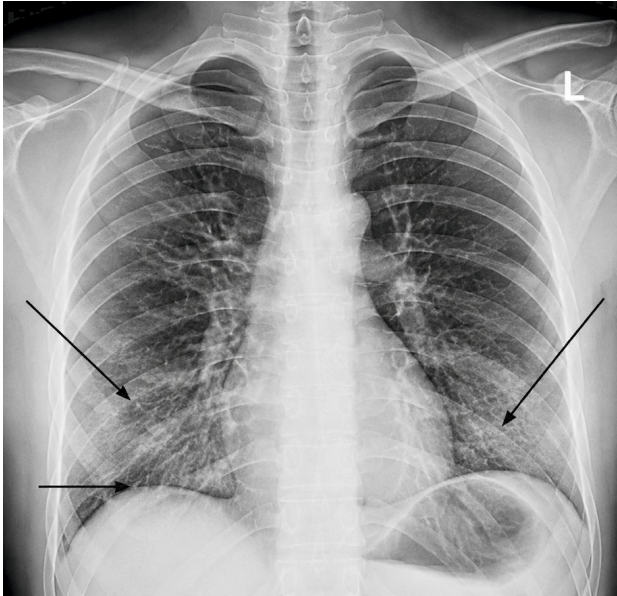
Chest radiograph showing bilateral diffuse patchy air-space opacities, predominantly in the mid and lower lung zones, consistent with alveolar hemorrhage.
